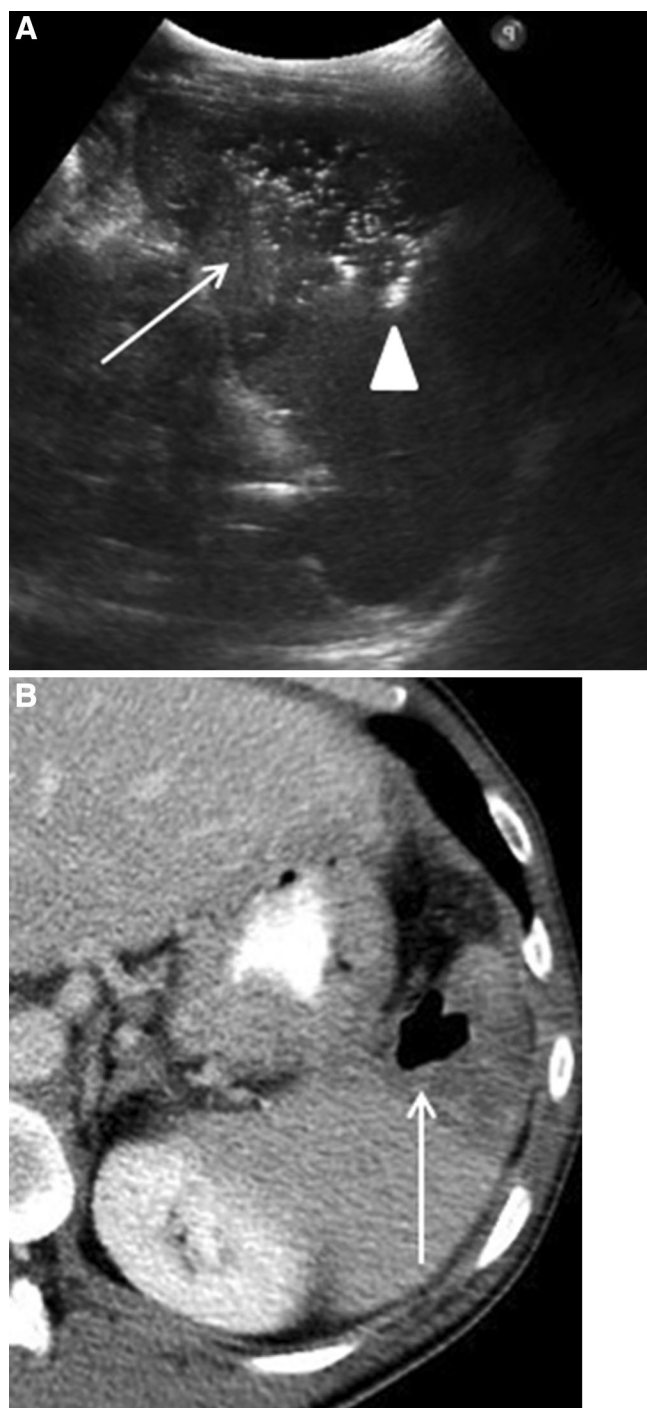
Pyogenic abscess of spleen. 65-year-old woman with fever and abdominal pain. A Longitudinal ultrasound image of the *left upper* quadrant shows a complex fluid collection (*arrow*) in the spleen with hyperechoic gas foci (*arrowhead*) consistent with abscess. B Axial contrast-enhanced CT confirms the sonographic findings of splenic abscess with a complex area of fluid attenuation and internal gas (*arrow*).
